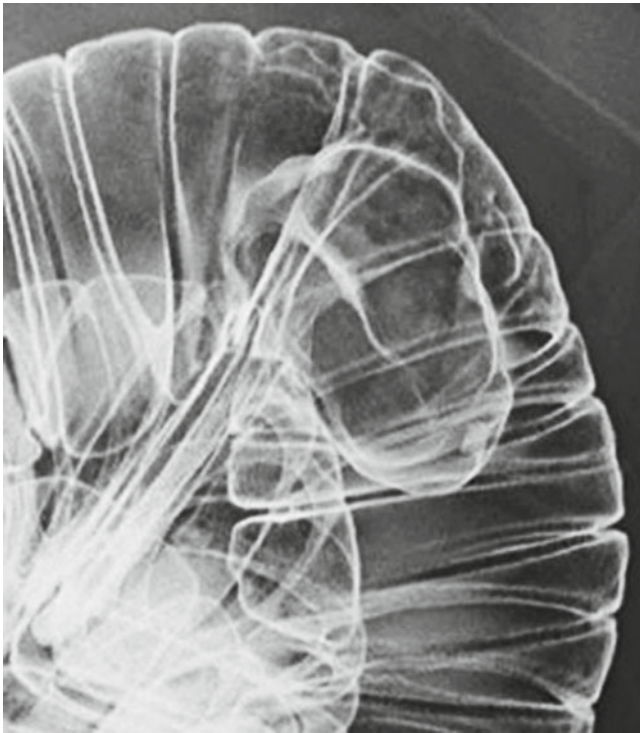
Radiography revealed a smoothly demarcated elevated lesion in the upper jejunum, with a distinct linear barium patch
